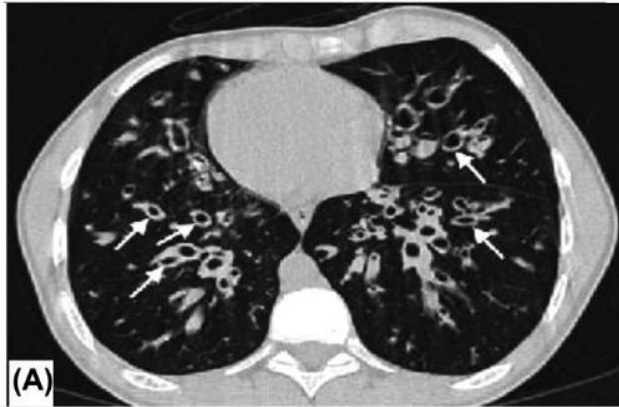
High resolution CT scan showing bronchiectasis and dextrocardia in person with PCD. Image reproduced from Tadd et al. (27 p.475) with permission from the publisher (license no. 5925280458149).
